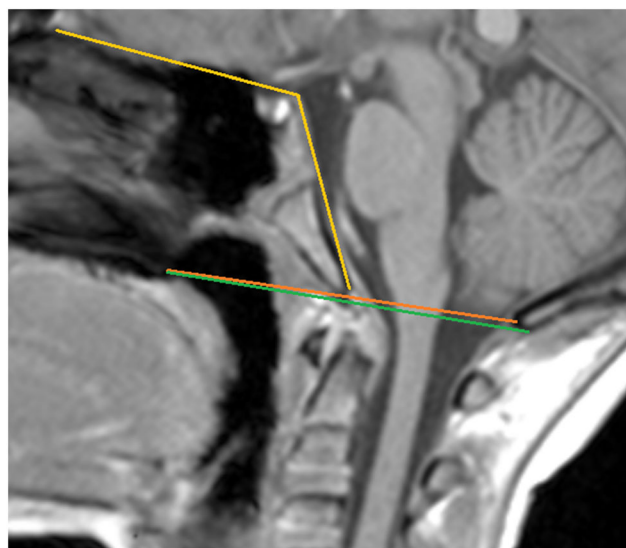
Demonstration of the three main measurements of the craniovertebral junction on a T1-weighted image of a pediatric patient. The distance between the Chamberlain (*brown*) and the McGregor (*green*) lines is small. The Welcher-basal angle (*yellow*) is formed by a line running from the nasion to the tuberculum sella and a second line running from the tuberculum along the posterior margin of the clivus. A Welcher-basal angle larger than 140° indicates platybasia
